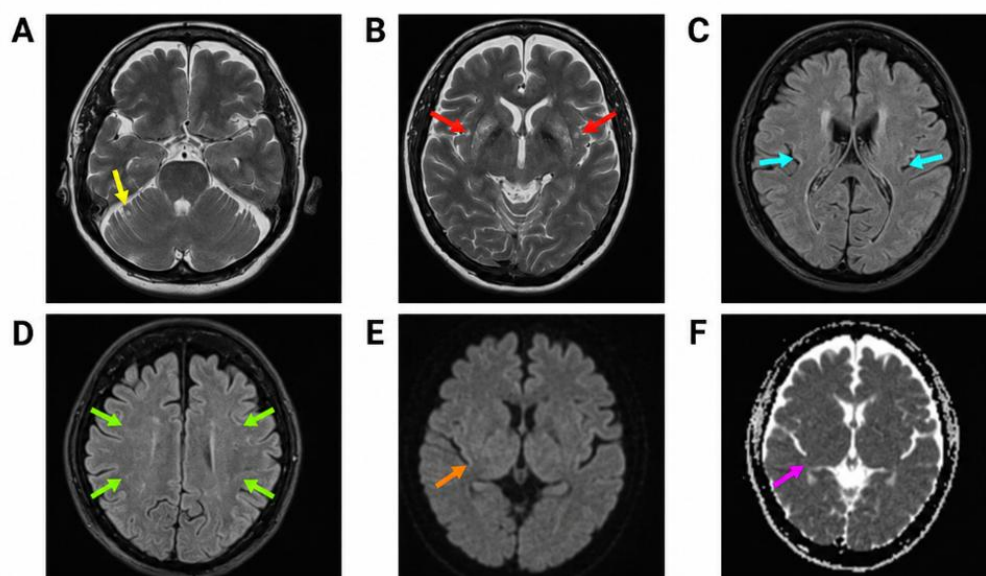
Brain magnetic resonance imaging findings.
